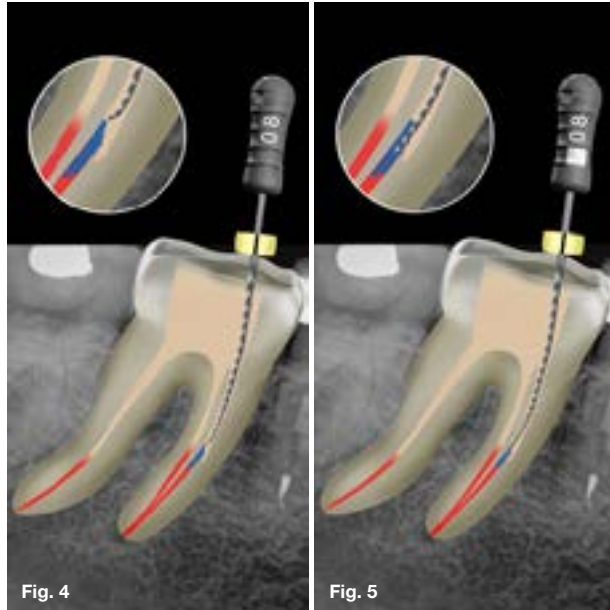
A size 08 C+-File (21 mm) with a distinct curve in the apical 2-3 mm of the file was selected in the attempt to bypass the ledge.
